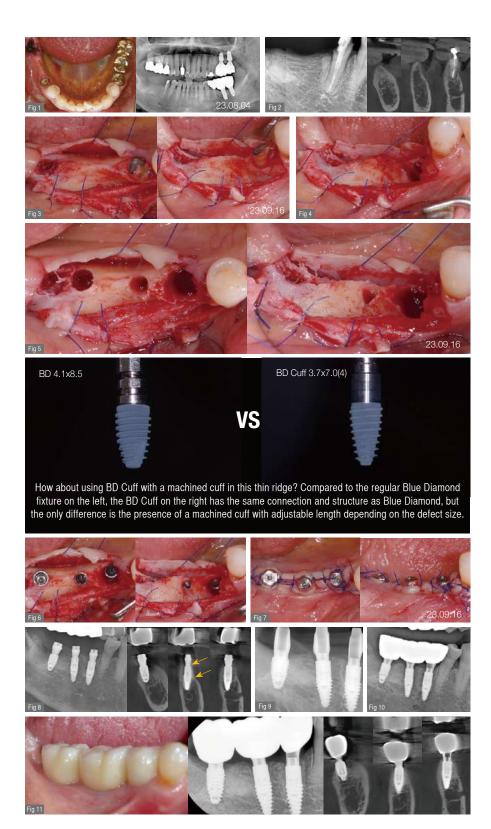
Postoperative panoramic and CBCT radiographs revealed minimal buccal bone thickness around the first molar implant, with the machined cuff of the BD Cuff occupying this space (indicated between the two arrows).
